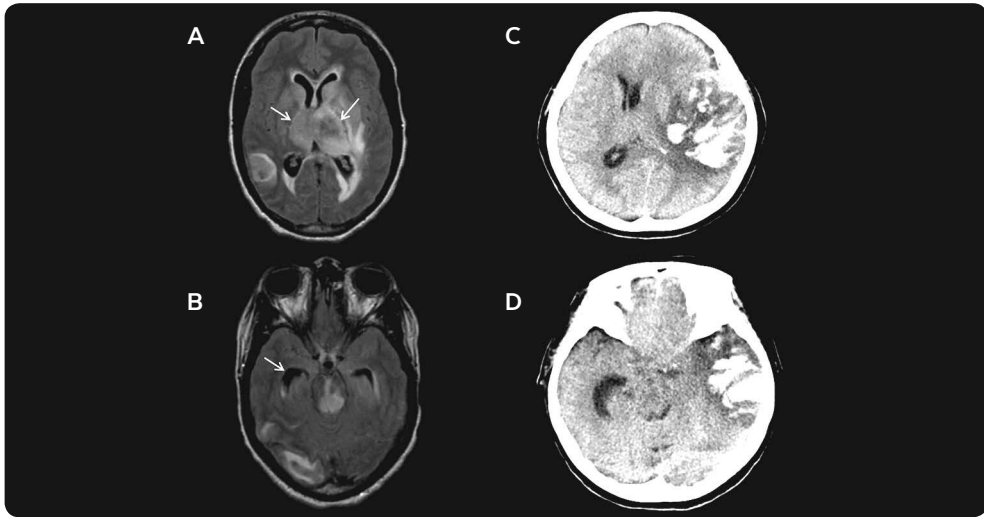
Cerebral imaging of 2 patients with hydrocephalus. *A and B:* Axial Fluid Attenuated Inversion Recovery (FLAIR) MRI showing extensive edema in the thalami, basal ganglia and brainstem, and hydrocephalus of both temporal horns (arrows). *C and D:* Axial non contrast-enhanced CT-scan showing a large space occupying intracranial hemorrhage in the left hemisphere, and an increase of width of the contralateral temporal horn.
